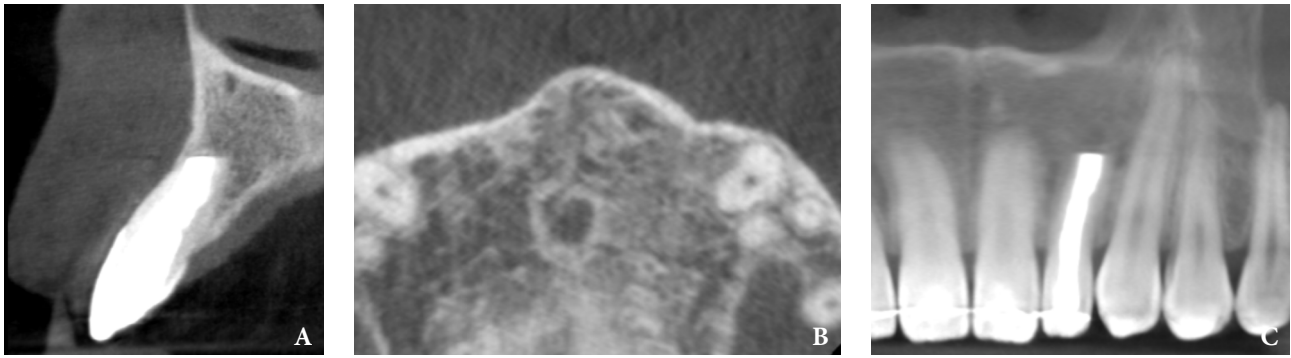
After the microsurgery, X-ray was performed on 17 August, 2020.
